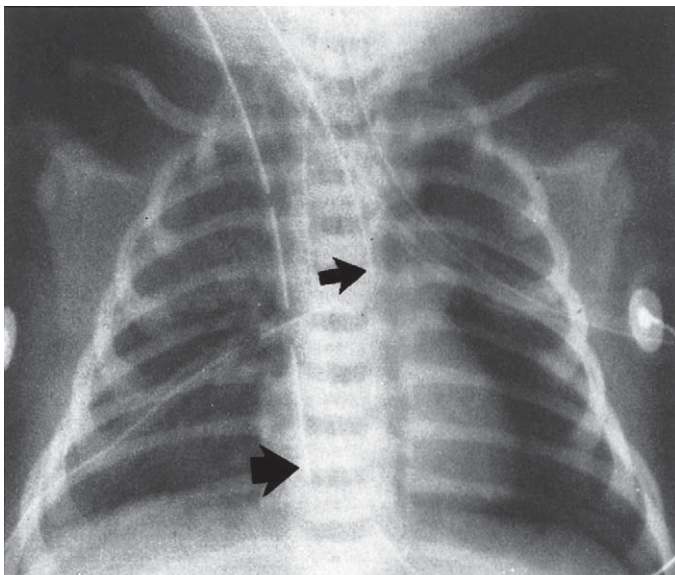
■ Chest radiograph in venoarterial extracorporeal membrane oxygenation patient showing the venous cannula (*large arrow*) in the right atrium, with the tip at the right atrium–inferior vena cava junction, and the arterial cannula (*small arrow*) in the aortic arch, with the tip directed down the descending aorta.
